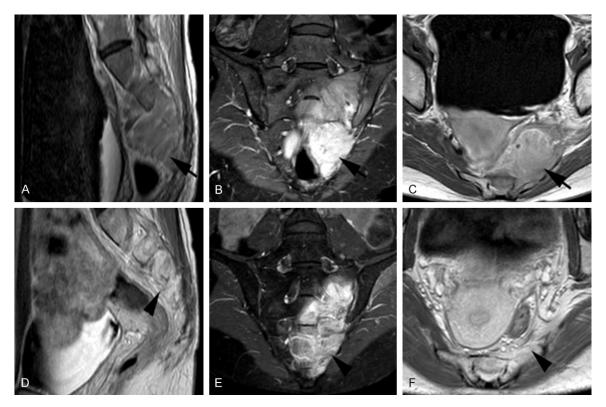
Sagittal, coronal, and axial T1WI and contrast-enhanced MRI scan of the spinal mass before (A-C) and after (D-F) two cycles of the induction chemotherapy. The sagittal scans revealed a mass on the sacral vertebrae with a clear margin and intermediate enhancement (arrow, A). The coronal T1WI SPIR and contrast-enhanced images showed that the mass was on the left side of the S3-S5 sacral vertebrae, with hyperintense upon enhancement (arrow, B). This was re-confirmed by the axial images (arrow, C). The tumor shrank remarkably after two cycles of induction with idarubicin and cytarabine (arrowheads, D-F). T1WI, T1-weighted; MRI, magnetic resonance imaging.
